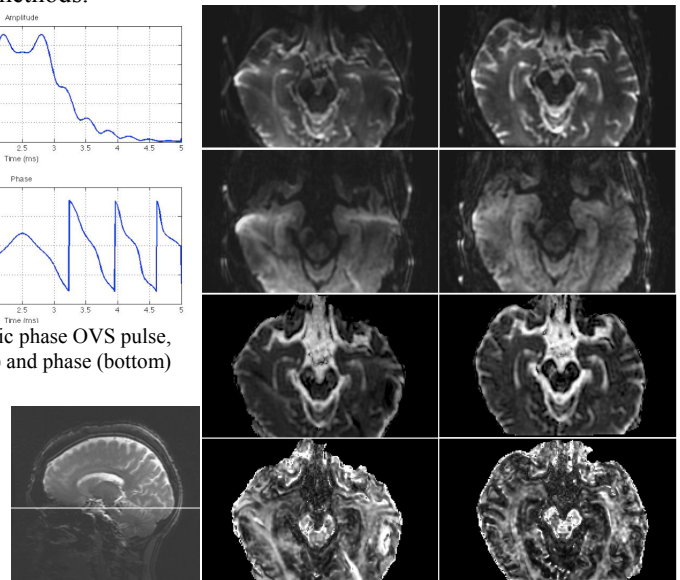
Axial DWI data from patient with early symptoms of dementia. Left column- standard acquisition incl. ASSET R=2 (zoomed to match coverage with reduced FOV data). Right column- reduced FOV acquisition. Row 1: b=0 images from slice through temporal lobes. Row 2: DWI images. Row 3: ADC maps. Row 4: FA maps. Bottom left: slice shown on sagittal localizer.
